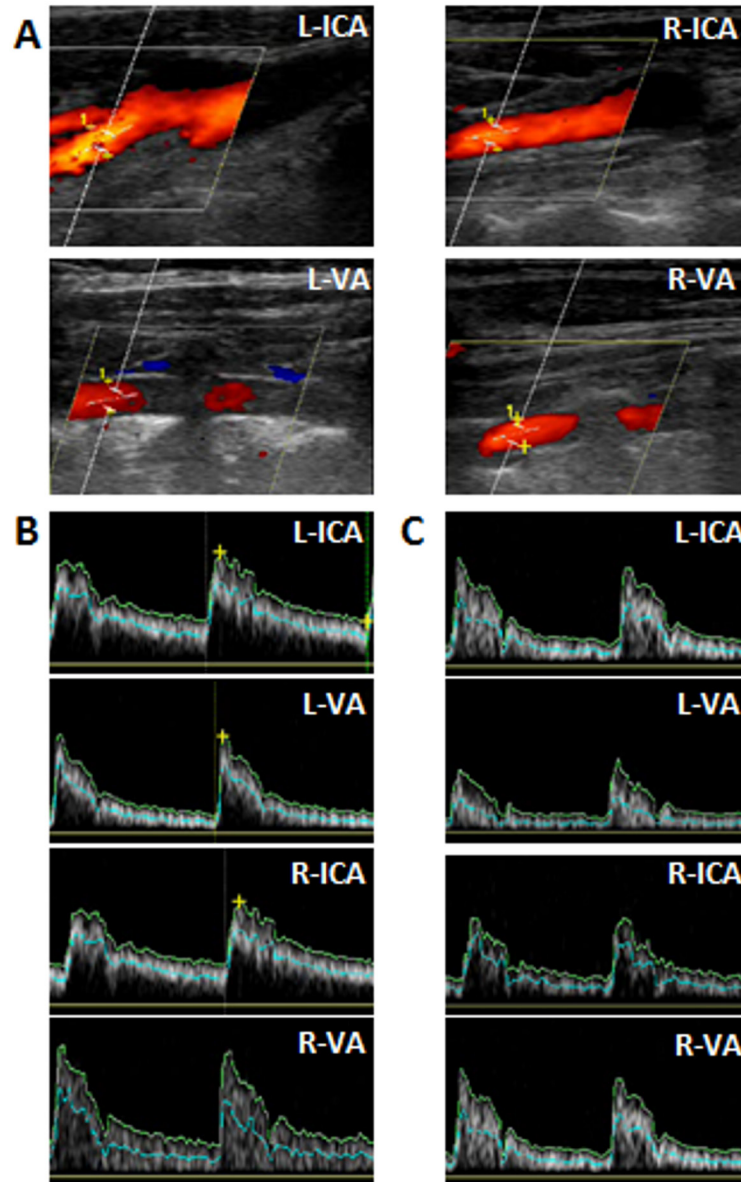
Quantification of Cerebral Blood Flow (CBF). In (A) the identification of both Internal Carotid Arteries (ICA) and Vertebral Arteries (VA) is shown in continuous colour Doppler images. The parallelogram shown in yellow indicates the colour box steer in the right-to-left/caudal-cephalic orientation of flow. The vessel diameter used for the quantification of CBF is measured for each artery and indicated as the number "1". (B) and (C) represent the blood flow velocity analysis (in cm/sec) during two cardiac cycles of two patients: patient represented in (B) has milder NIHSS at admission, flow diversion and higher CBF than the patient in (C). The blue line in each flow analysis represents the mean flow velocity (used for CBF quantification) and the yellow line indicates the maximum flow velocity.
